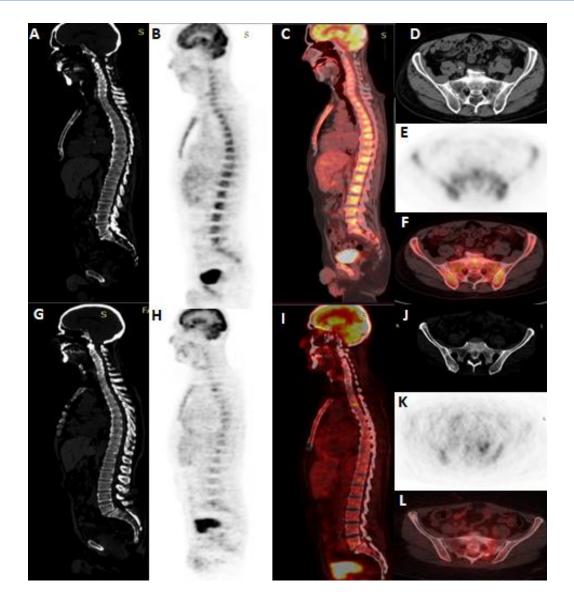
52-year-old male with pathologically confirmed DLBCL and negative iliac crest biopsy for BM infiltration, the sagittal images (A, B, and C), as well as the axial cuts of the pelvis (D, E, and F), revealed metabolically active FDG avid widespread mixed lytic and sclerotic osseous deposits (predominantly sclerotic) involving most of the axial and appendicular skeleton. Sternal biopsy confirmed Positive BM infiltration. The lower raw images of the same cuts (G, H, I, J, K, and L) showed mild regression in the activity of previously reported lesions, with a reduction of SUVmax from 9.8 to 6.7 in the most active lesion (LV2).
